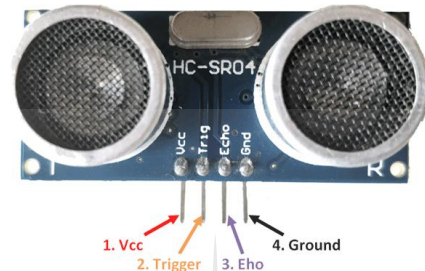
Ultrasonic sensor
